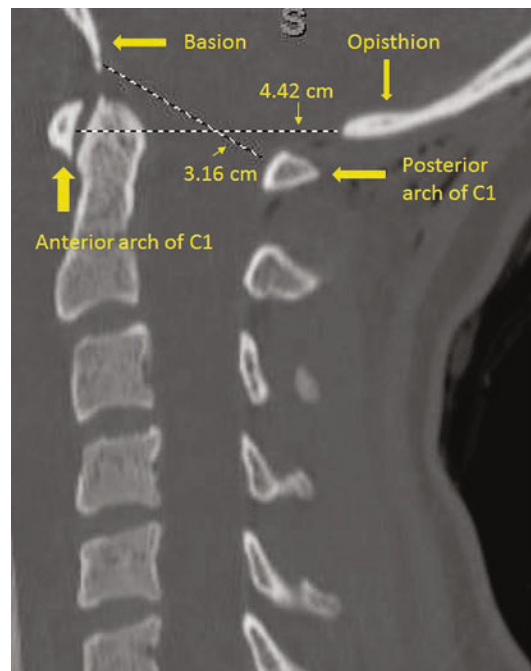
Sagittal CT of the cervical spine without contrast demonstrating the measurement of the Powers ratio (calculated by dividing the measurement between the tip of the basion to the spinolaminar line by the measurement from the tip of the opisthion to the midpoint of the posterior aspect of the anterior arch of C1). In the patient shown here, the calculation would be $3.16/4.42 = 0.71$. A ratio > 1.0 suggests cranial-cervical instability
